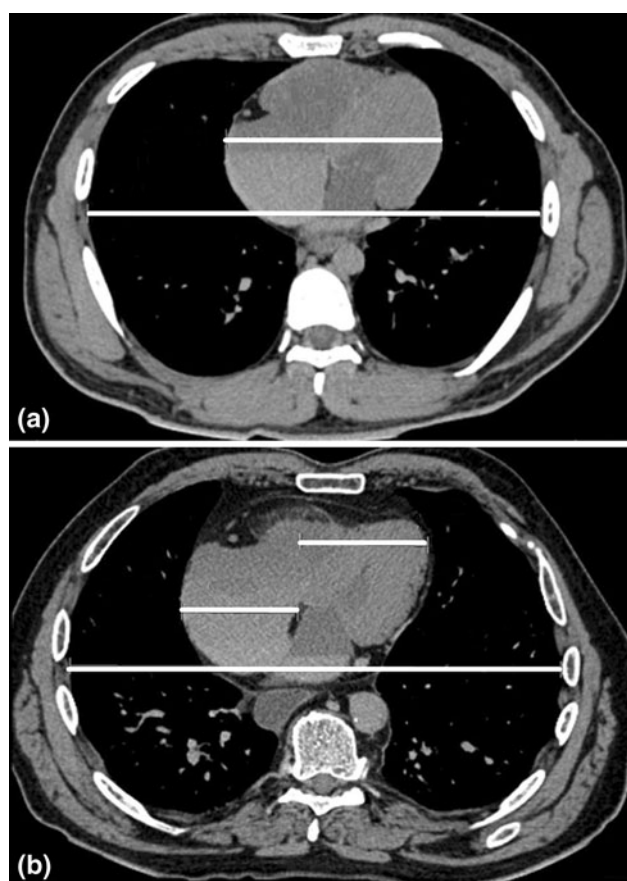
Axial CT images of the thorax. Lines were drawn for the maximum thoracic diameter and for the maximum cardiac diameter in transverse direction (a). In cases where the maximum diameter of the heart was not assessable with one measurement (b), lines were divided according to the method of Ungerleider and Gubner [6]. Line placement was not necessarily in the same level of the axial slices
